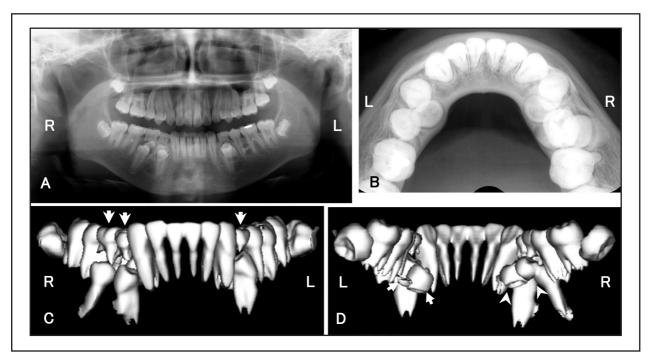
(a) The panoramic radiograph. (b) Occlusal radiograph of the mandible. (c) A labial view of the three-dimensional (3D) mandibular image. The primary molars were extracted (arrows). (d) A lingual view of the 3D mandibular image. Four supernumerary teeth were lingual to impacted premolars. Two supernumerary teeth were extracted (arrowheads), and the other 2 supernumerary teeth were left in situ (arrows).
